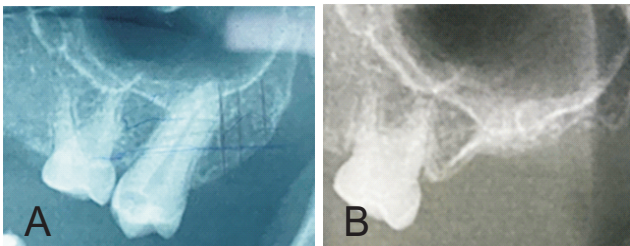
Pre and Post Operative radiograph after maxillary tuberosity reduction.
